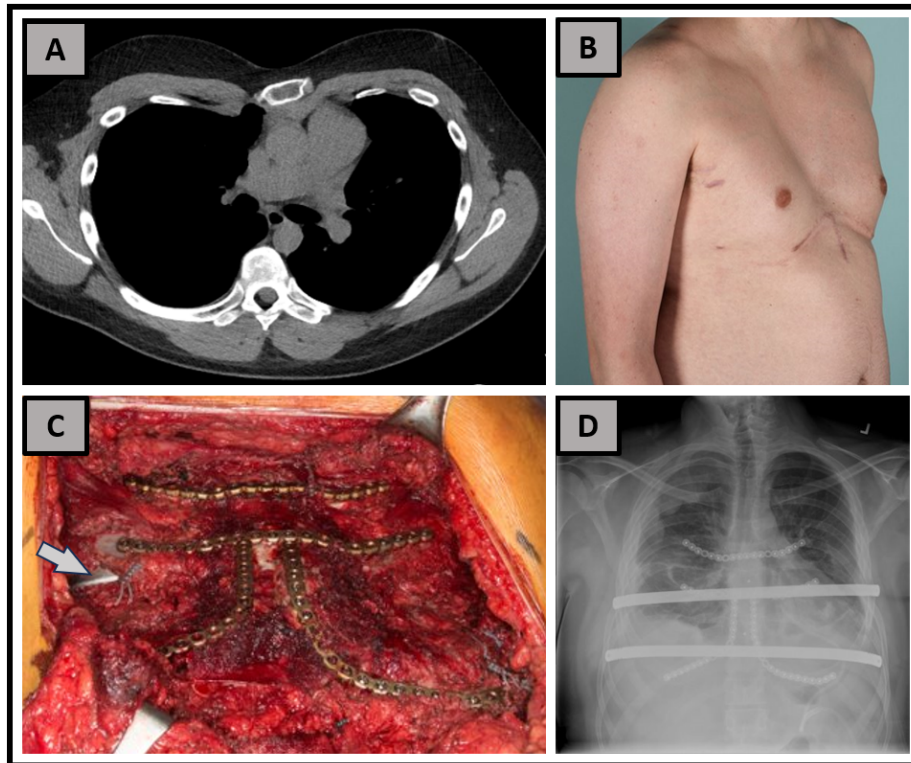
(A) Pre-revision chest Computerized Tomography of a patient with a history of 2 prior Ravich procedures. (B) Anterior gross view of the patient's chest deformity. (C) Intraoperative photograph of the patient after undergoing a Complex Hybrid Reconstruction (Arrow points to the upper Nuss bar). (D) Anterior-Posterior Chest Xray of the patient after the reconstruction with 2 Nuss support bars and multiple titanium plates.
